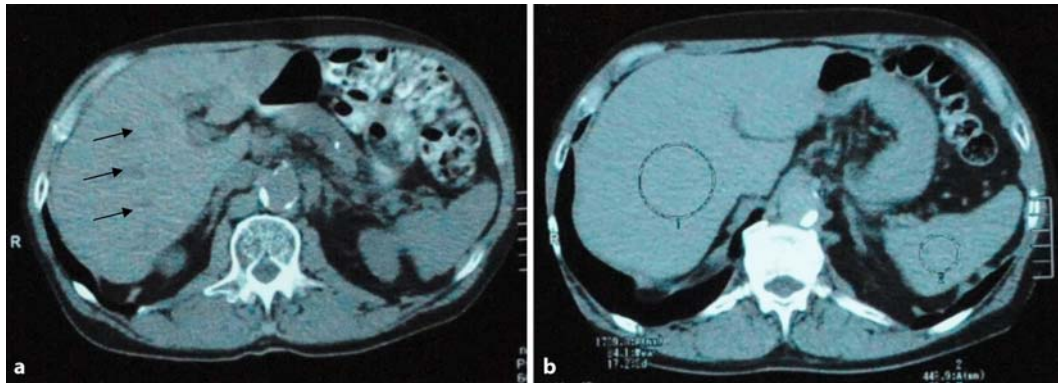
CT scans of liver metastases in a patient with an adenocarcinoma of the rectum: a at diagnosis of the metastases (January 2008) and b after 6 months (August 2008) of fourth-line treatment with panitumumab (case 2).
